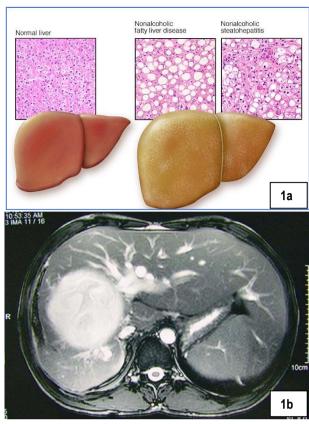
Shows normal liver vs Nonalcoholic fatty liver disease and x-ray of Nonalcoholic fatty liver³
